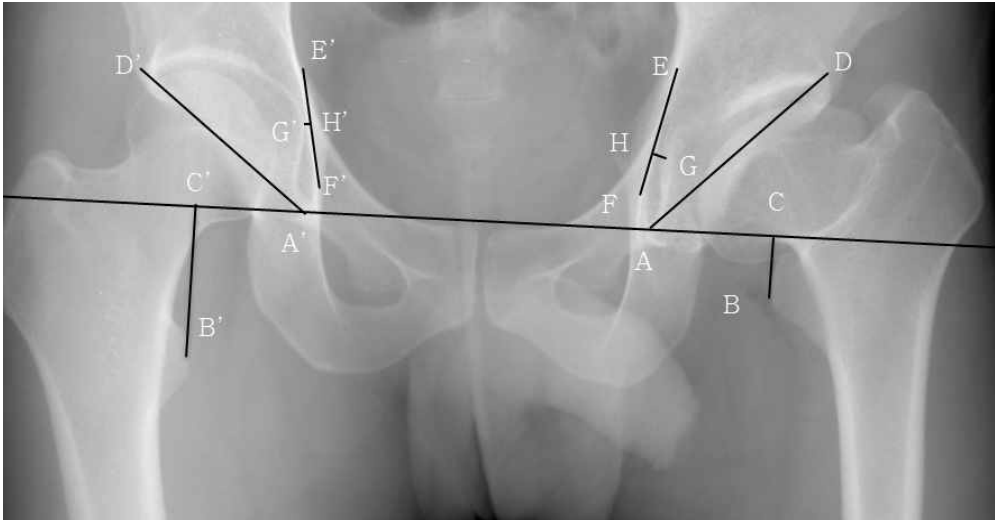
Preoperative radiograph with a patient with Legg–Calve–Perthes disease sequelae. Leg length discrepancy ($\overline{B'C'} - \overline{BC}$) was measured by comparing vertical distance (\overline{BC}) from inter–teardrop line ($\overline{AA'}$) to summit of lesser trochanter (B). Acetabular index ($\angle DAC$) was measured by angle between inter–teardrop line ($\overline{AA'}$) and line connecting teardrop (A) and lateral lip of acetabulum (D). Medial wall thickness (\overline{GH}) was measured by shortest distance from ilioischial line to medial wall of acetabulum.
